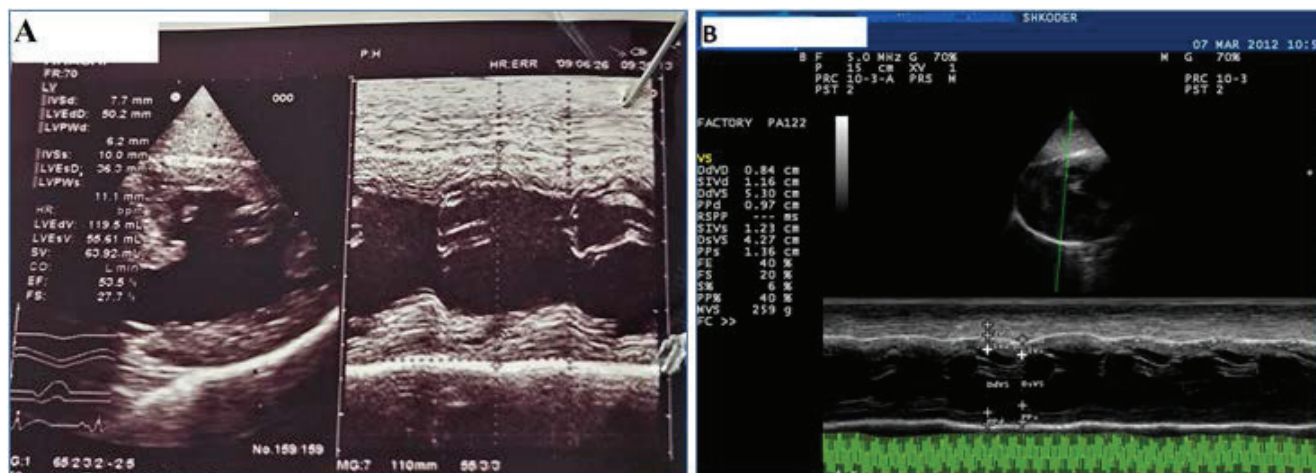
(A on 26/06/2009 first echocardiography, B echocardiography on 07/03/2012)
